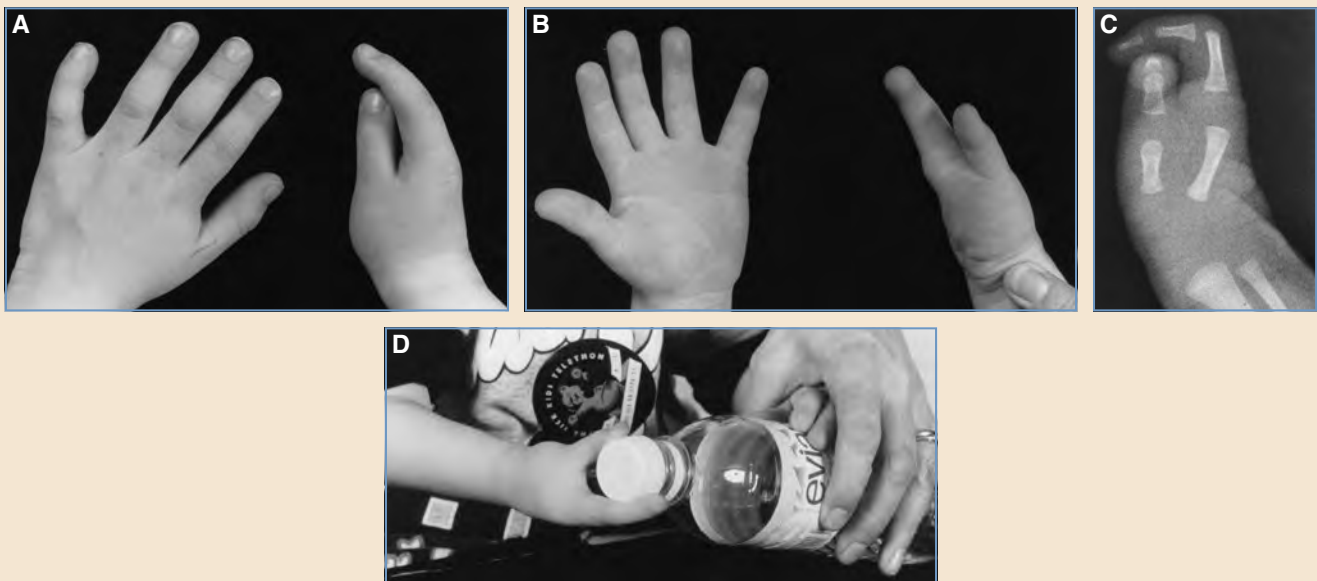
A and B, A two-fingered cleft hand with a sufficient web between the digits may prove very functional and not warrant reconstruction. C, A radiograph shows the two digits positioned in an excellent orientation for grasp. D, Hand function could not be improved with surgery.
